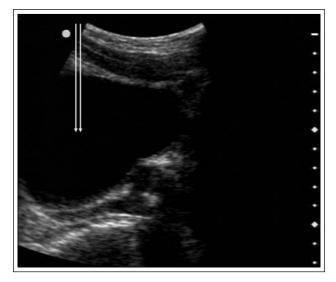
A mid-sagittal ultrasound image of a human (male) urinary bladder, taken with a portable ultrasound system. The double arrow shows an example of the needle path for bladder catheterization, which does not penetrate the peritoneal space when the bladder is distended.
